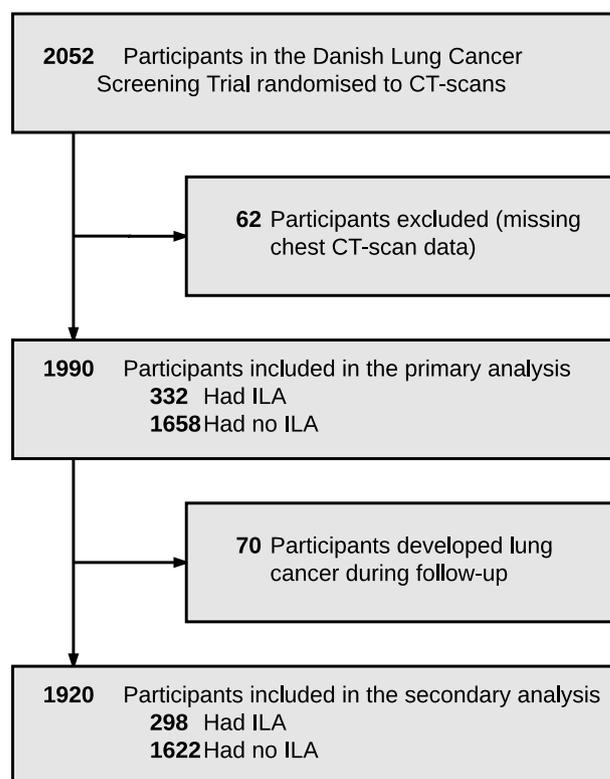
Generation of the study population for this follow-up study from the intervention arm of the Danish Lung Cancer Screening Trial (DLCST). All participants with chest CT scan data were included in the primary analysis and all participants that remained lung cancer free during follow-up were included in the secondary analysis. ILA: interstitial lung abnormalities.
